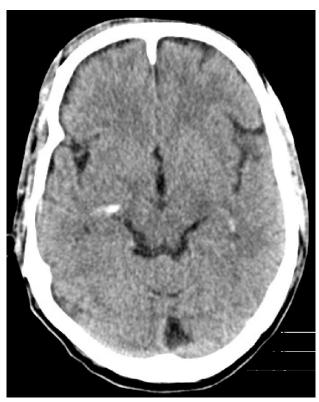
Plain CT scan at brain window images shows subtle symmetric comma shaped calcifications in medial aspect of the temporal lobes that is classically seen in LP
